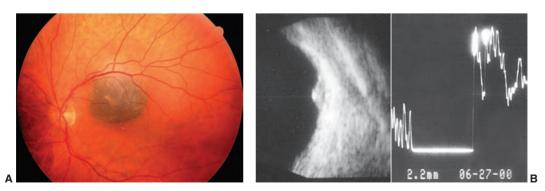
Small untreated choroidal melanoma observed over 2 years without change in clinical appearance. (A) Clinical appearance. (B) Ultrasonogram demonstrating dome-shaped choroidal mass measuring 2.2 mm in vertical height.
